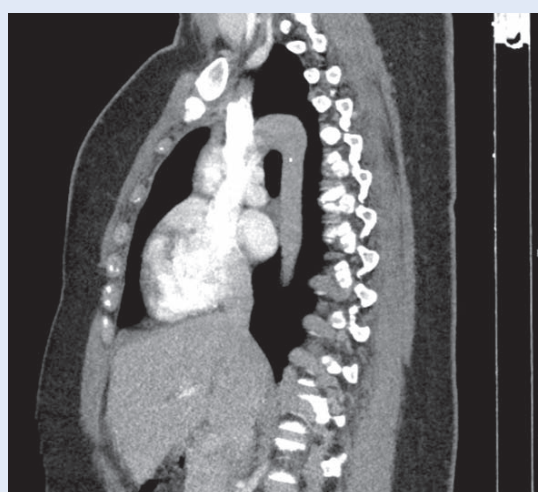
Sagittal abdominal CT scan – No representation of the inferior v. cava in the area from the renal veins to the heart.
